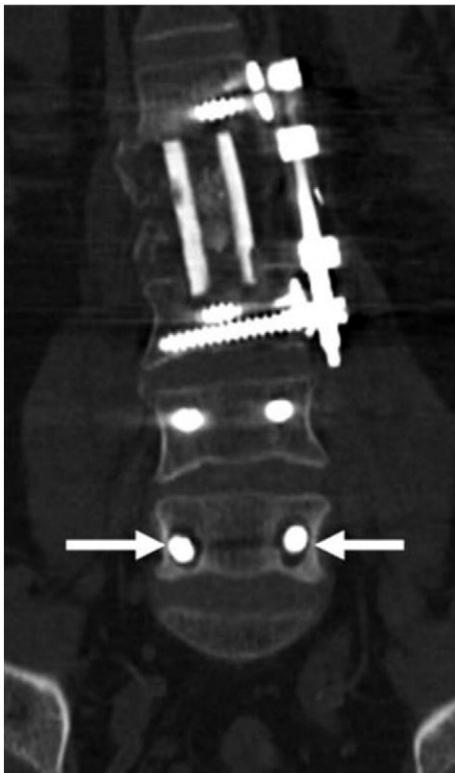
Coronal computed tomography image clearly shows areas of lucency around the inferior pedicle screws (arrows). (Image provided courtesy of The Radiological Society of North America. From Young et al.¹.)
